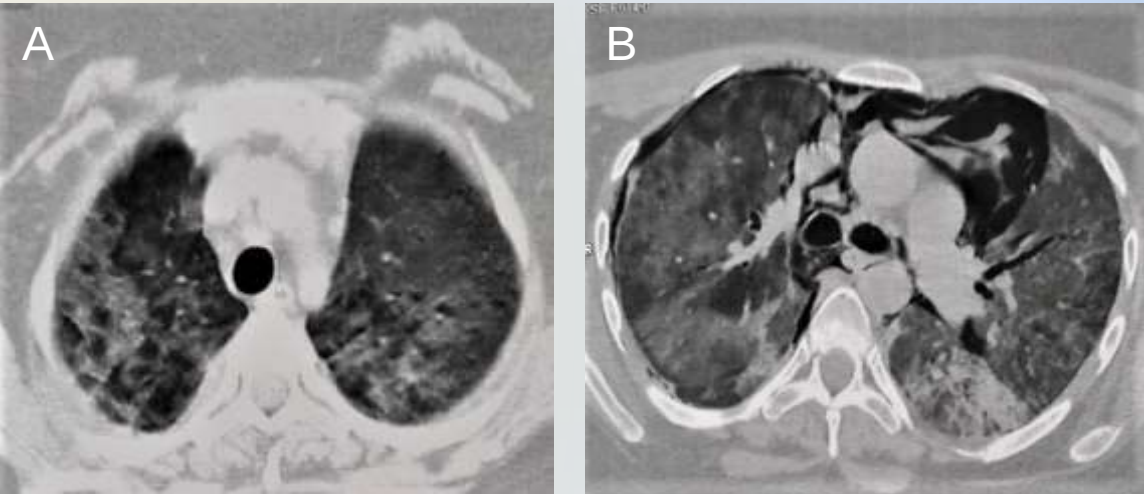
32 year-old female patient presenting with fever and cough. The PCR test was positive for COVID-19. Initial non-contrast CT:
